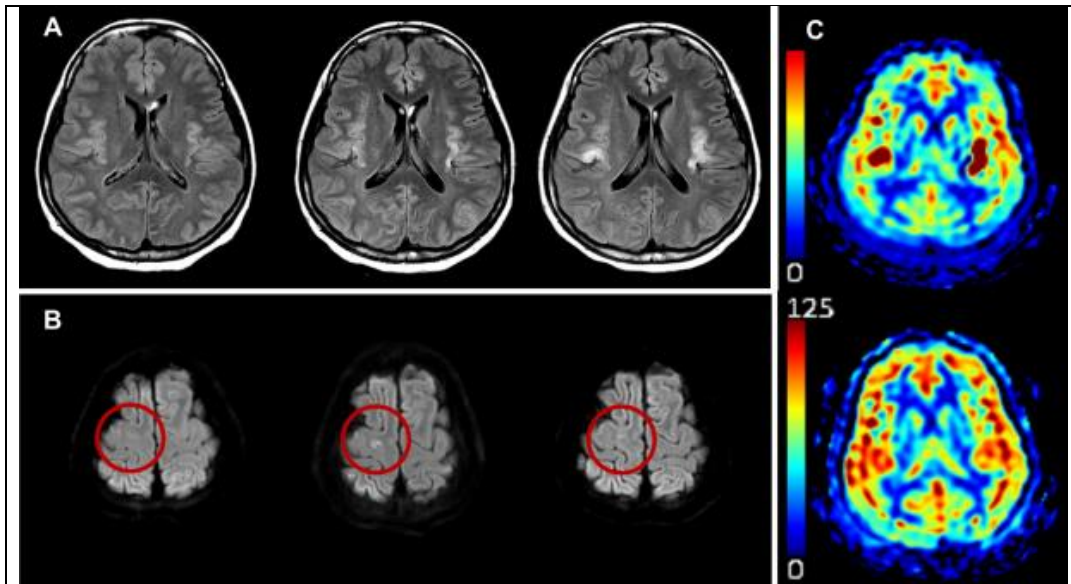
Magnetic resonance imaging findings along the treatment period
